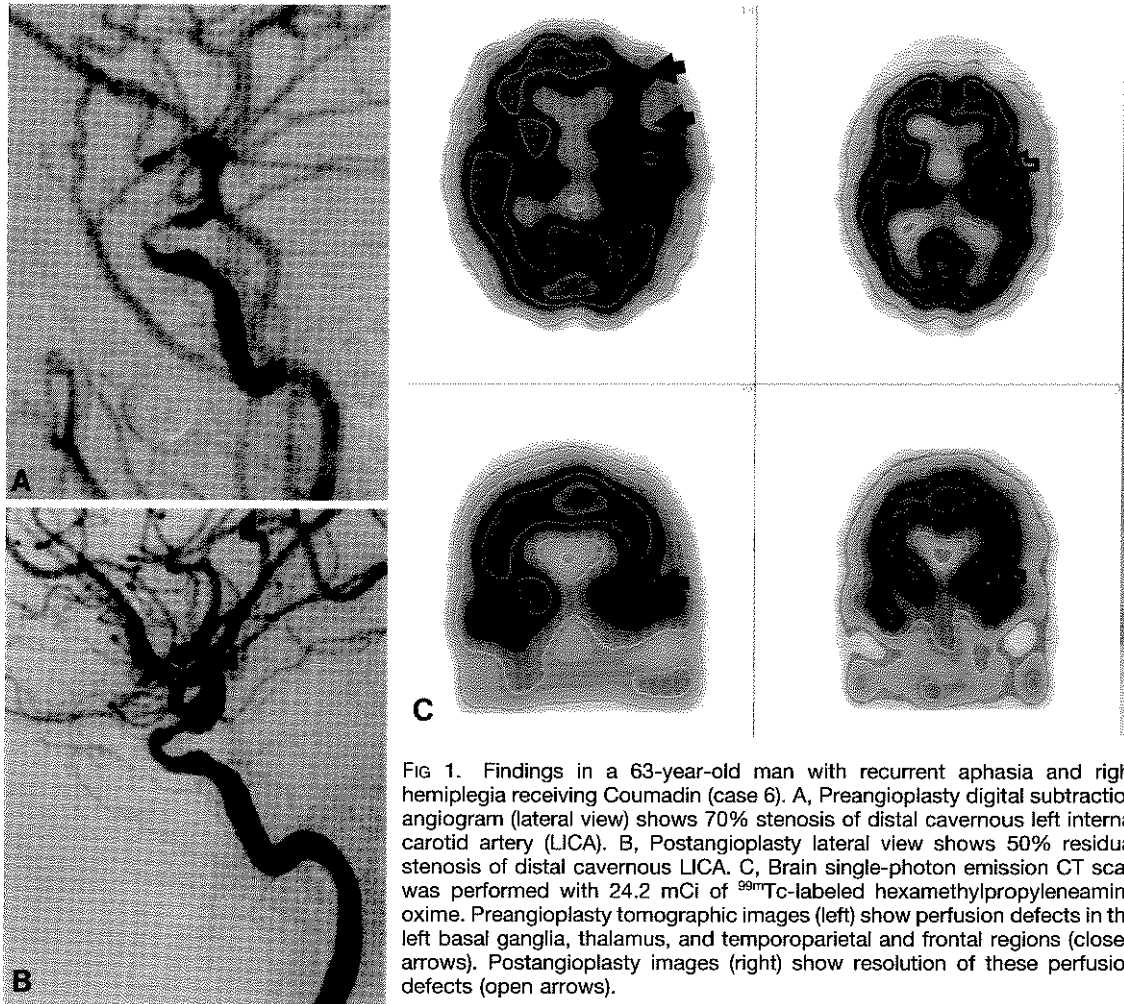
Findings in a 63-year-old man with recurrent aphasia and right hemiplegia receiving Coumadin (case 6). A, Preangioplasty digital subtraction angiogram (lateral view) shows 70% stenosis of distal cavernous left internal carotid artery (LICA). B, Postangioplasty lateral view shows 50% residual stenosis of distal cavernous LICA. C, Brain single-photon emission CT scan was performed with 24.2 mCi of ^{99m}Tc -labeled hexamethylpropyleneamine oxime. Preangioplasty tomographic images (left) show perfusion defects in the left basal ganglia, thalamus, and temporoparietal and frontal regions (closed arrows). Postangioplasty images (right) show resolution of these perfusion defects (open arrows).
